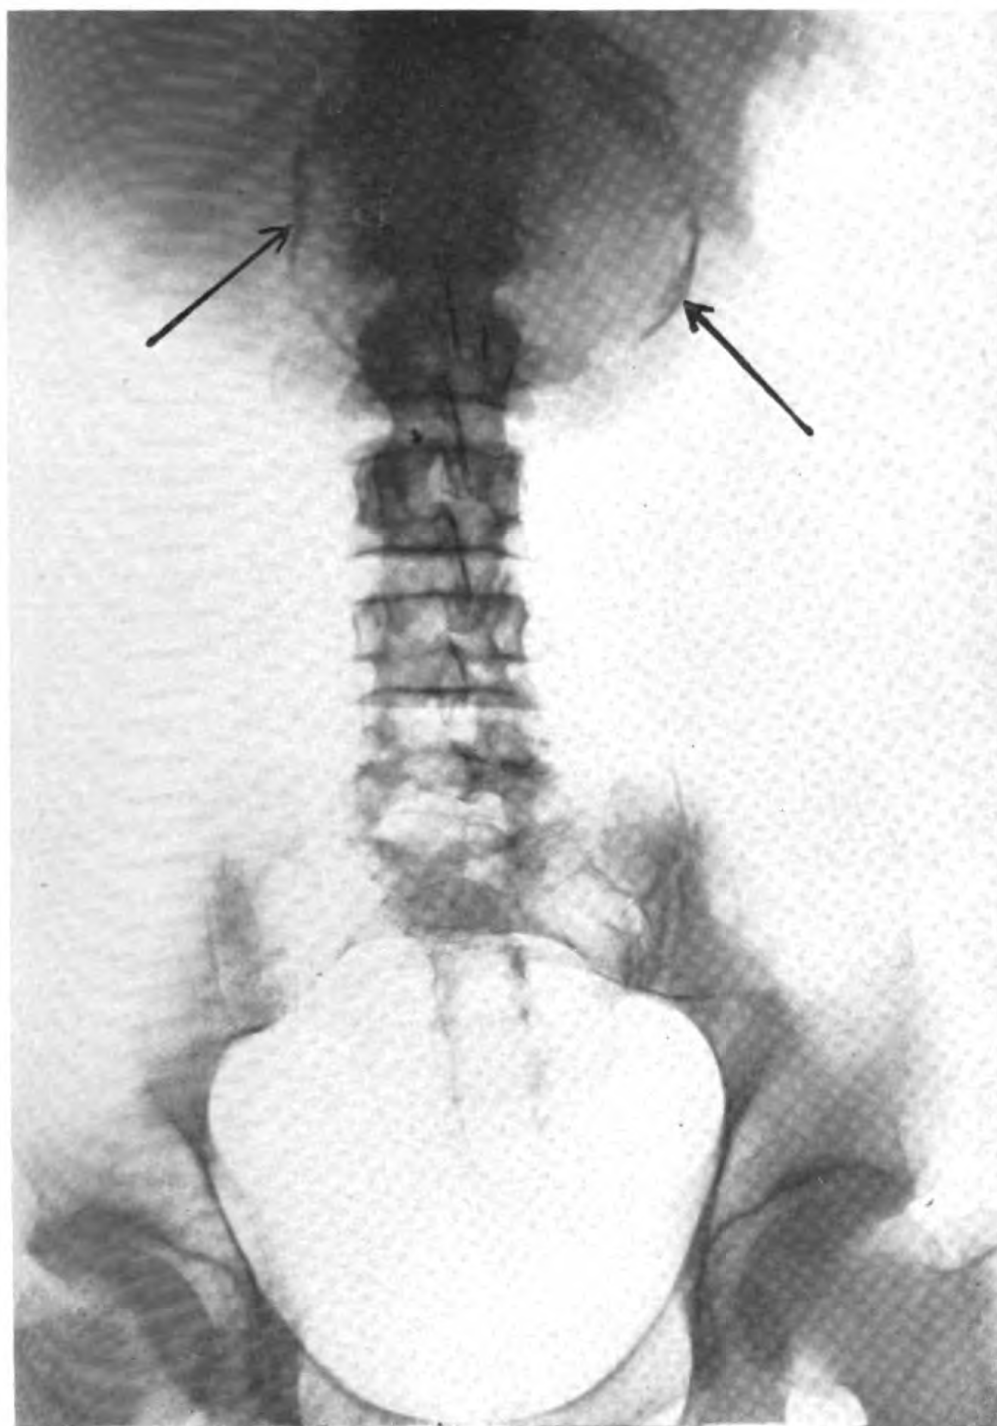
X-RAY OF ABDOMEN SHOWING CALCIFIED WALL OF ANEURYSM.
